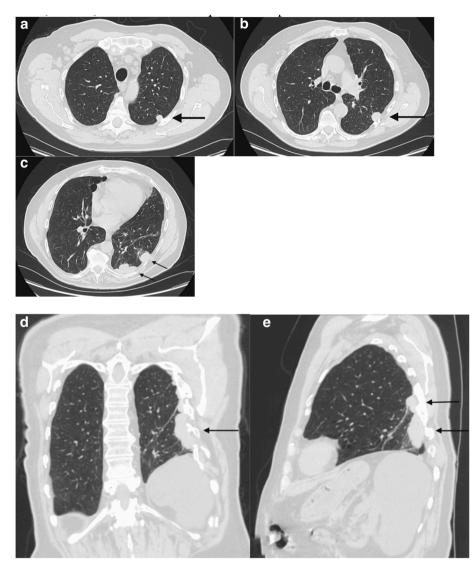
CT axial (a, b, c), coronal (d), and sagittal (e) images showing numerous pleural base nodules along the left posterior and posterolateral chest wall (*arrows*). Sizes ranged from 1.2 cm, 2 cm, 3.4 cm, 5 \times 2.4 cm on the posterior aspect of the LLL.
